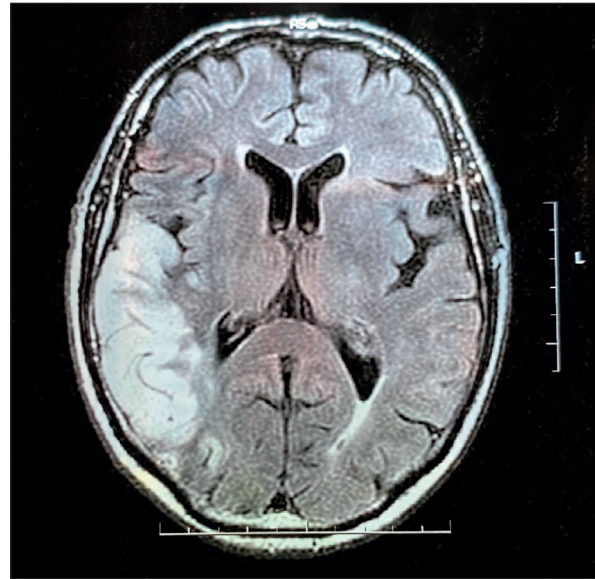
T2-FLAIR brain MRI images, demonstrating a hyperintense area in the right temporo-parieto-occipital (TPO) junction and subcortical white matter, consistent with a subacute infarction, about the size of 78x34x43 mm.
